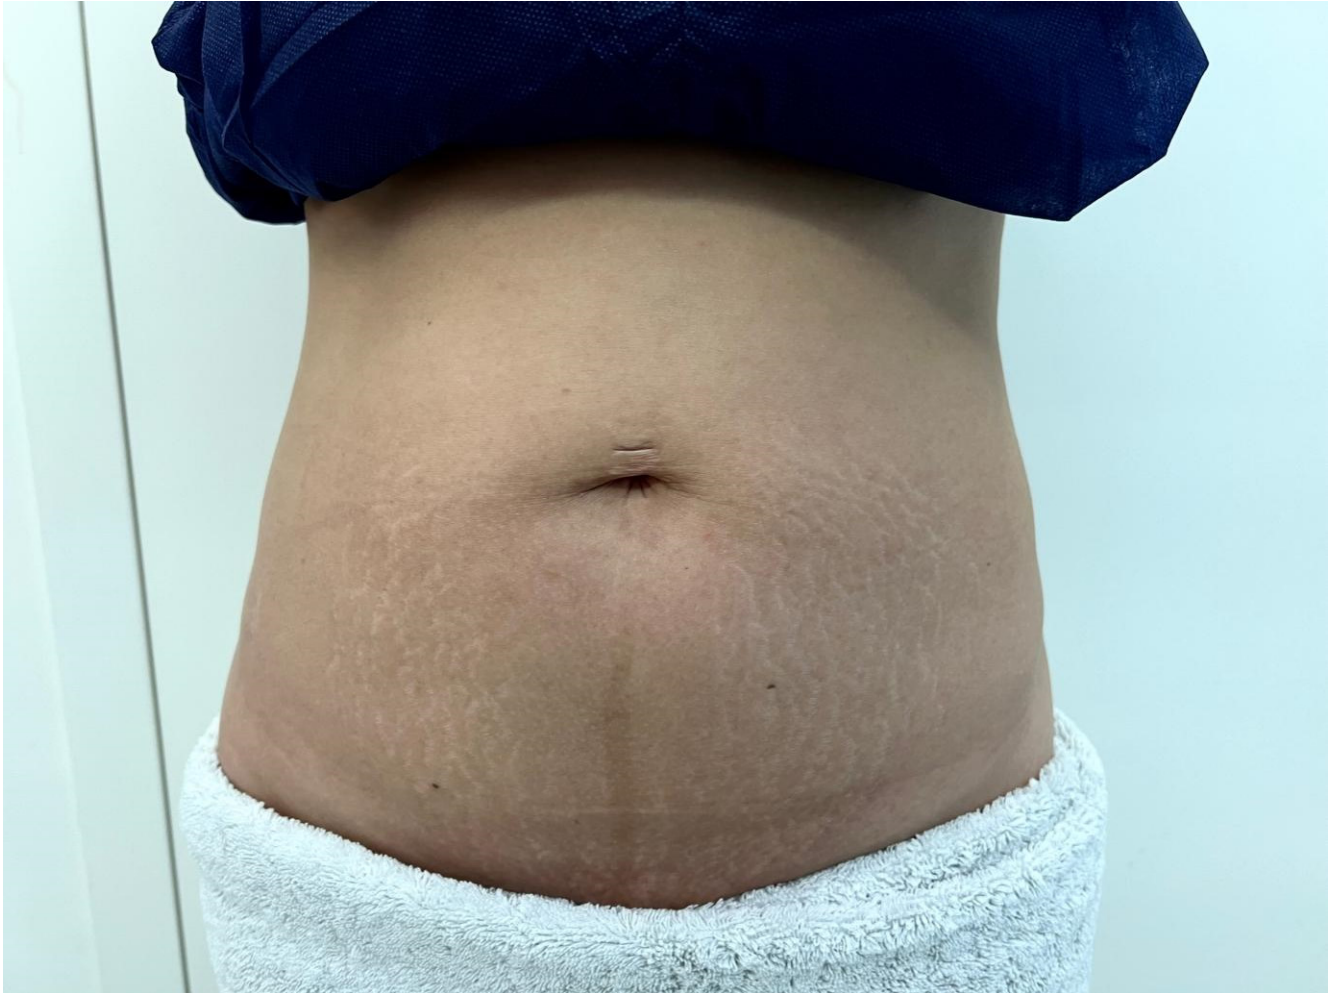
Case 3, Microfocused Ultrasound 850 shots + 5 mL diluted CaHA + 50 U IncoBTX-A to the left side of abdomen only (4 weeks after treatment).
